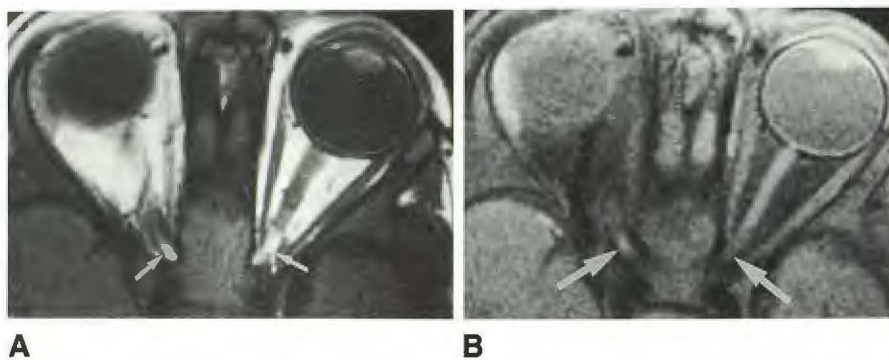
Normal volunteer. A, Axial T1-weighted image (600/20/2). Intracanalicular portion of optic nerves was obscured by high-signal fat (arrows). B, Axial T1-weighted image with fat suppression. Intracanalicular portion of optic nerves (arrows) is seen much better on fat-suppression image.
